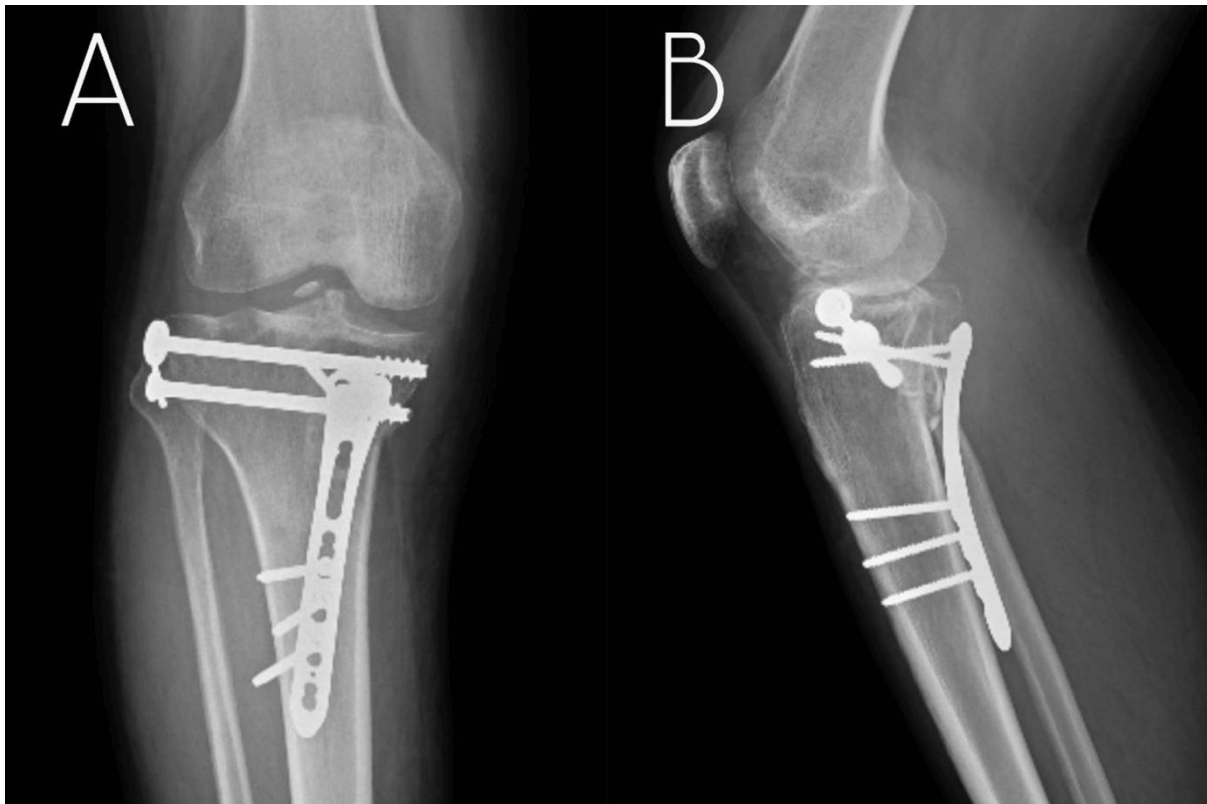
Post-operative radiograph in anteroposterior and lateral view
